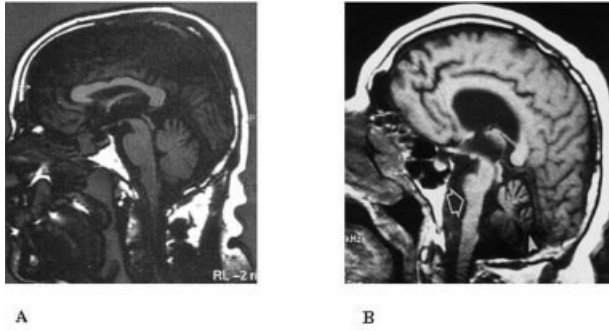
Mid-sagittal T1 brain magnetic resonance imaging (MRI) scan of the proband (A) documents the absence of pontocerebellar atrophy, which in contrast is evident in the corresponding MRI images of a typical spinocerebellar ataxia type 2 (SCA2) patient (B, marked by arrows).
